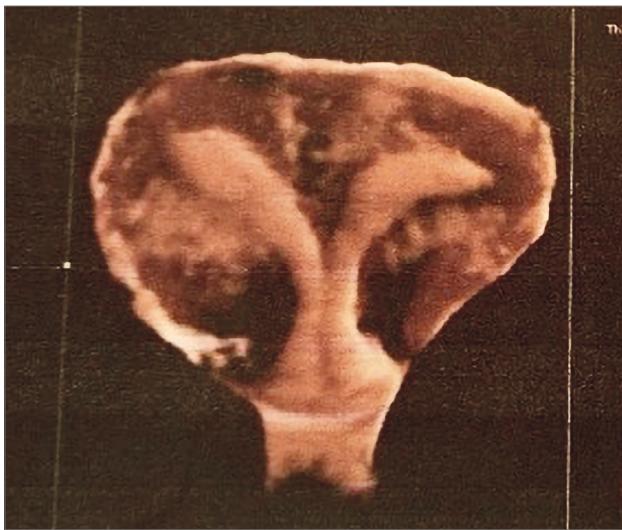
3D image of complete uterus duplication, which is made during transvaginal ultrasound of the pelvic organs
